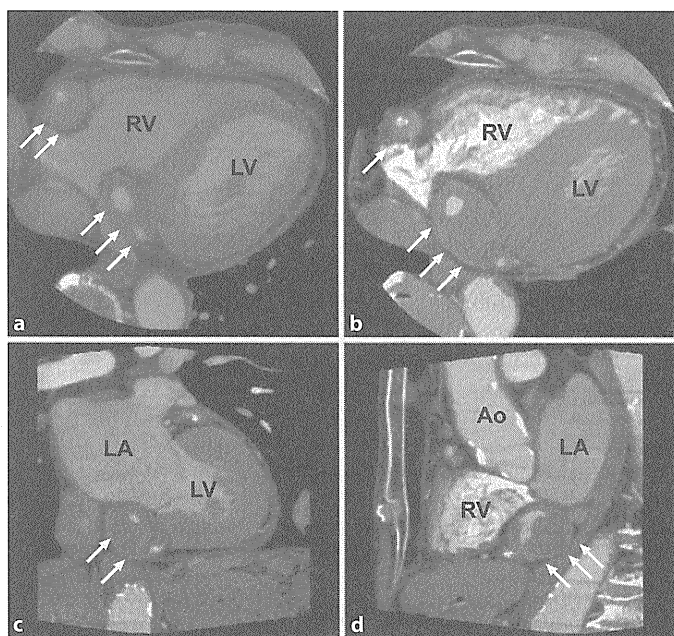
Cardiac computed tomography on first admission (a) and 4 months later (b-d). RV = Right ventricle; LV = left ventricle; LA = left atrium; Ao = aorta. a Horizontal view of cardiac computed tomography on first admission demonstrating focal tumorous lesions surrounding the right coronary artery (arrows). b-d Four months later, the tumorous tissue in the distal portion (arrows) enlarged, as shown by horizontal (b), coronal (c) and sagittal view (d).
